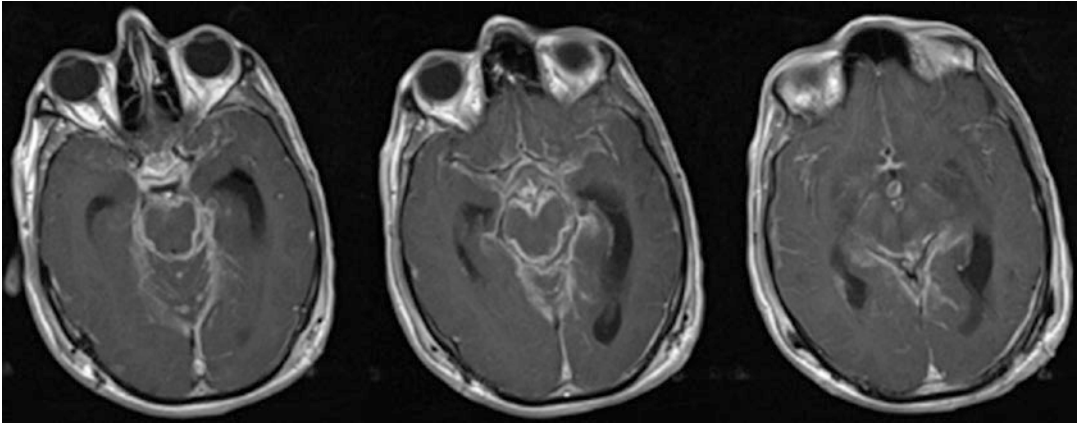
Meningeal TB. Axial post-contrast T1-weighted MRIs demonstrate enhancing basilar exudates and leptomeningeal enhancement
